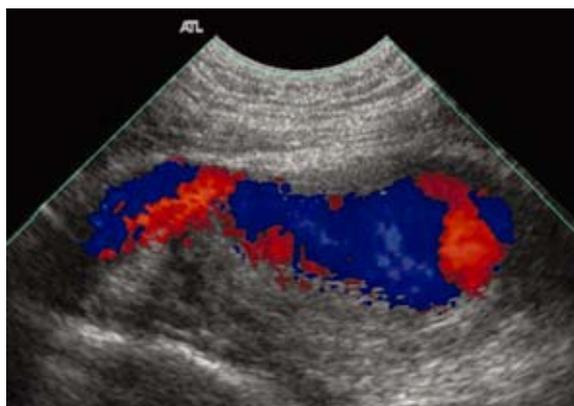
Colour Doppler US image shows an aneurysmal dilatation of an artery in the right gluteal region, with turbulent flow and thrombus formation within.
